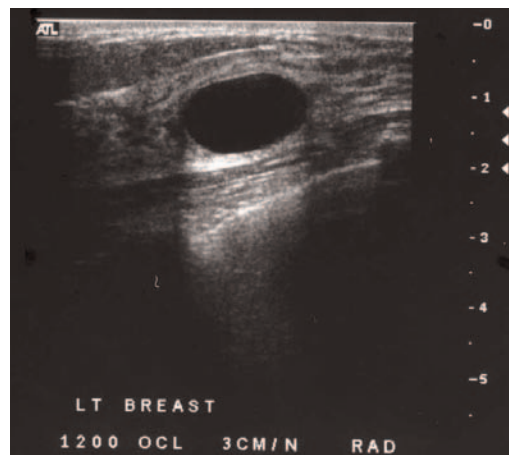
Simple cyst displaying classic sonographic characteristics.
